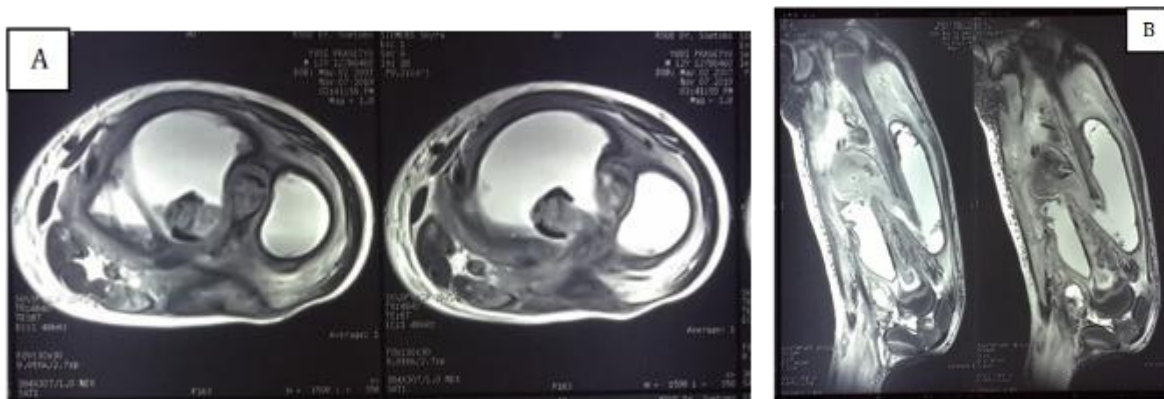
(A) MRI of the axillary femoral axis in T2 sequence. (B) MRI of the sagittal section of the femur in the T2 sequence.
